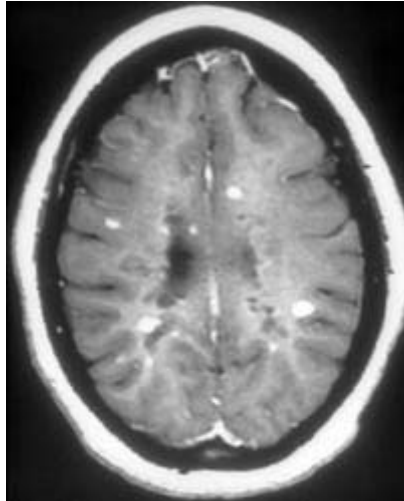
This MRI scan with gadolinium enhancement shows active plaques (bright areas). Image courtesy of Gordon Sze, MD.
